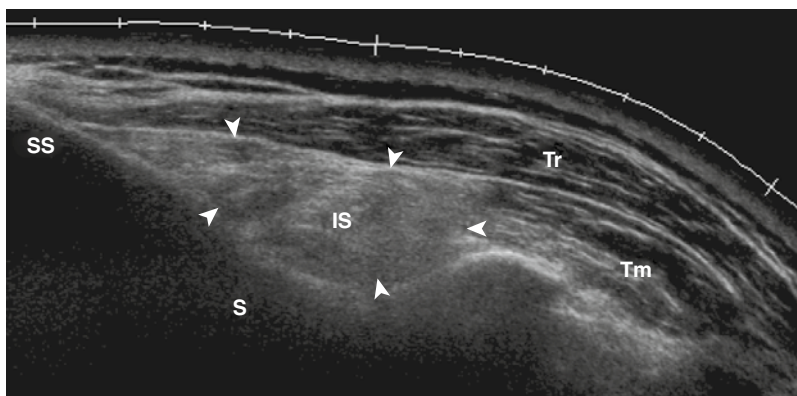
DENERVATED MUSCLE ATROPHY. Short-axis, 5- to 14-MHz, extended-view ultrasound image over the dorsal aspect of the scapula shows selective atrophy and fatty infiltration of the infraspinatus muscle (IS) (arrowheads) in a patient with a suprascapular nerve traction lesion obtained during a motor vehicle accident. Notice the normal hypoechoic aspect of the intact trapezius (Tr) and teres minor (Tm) muscles, compared with the hyperechoic aspect of the denervated infraspinatus muscle. S, scapula; SS, spine of the scapula.
